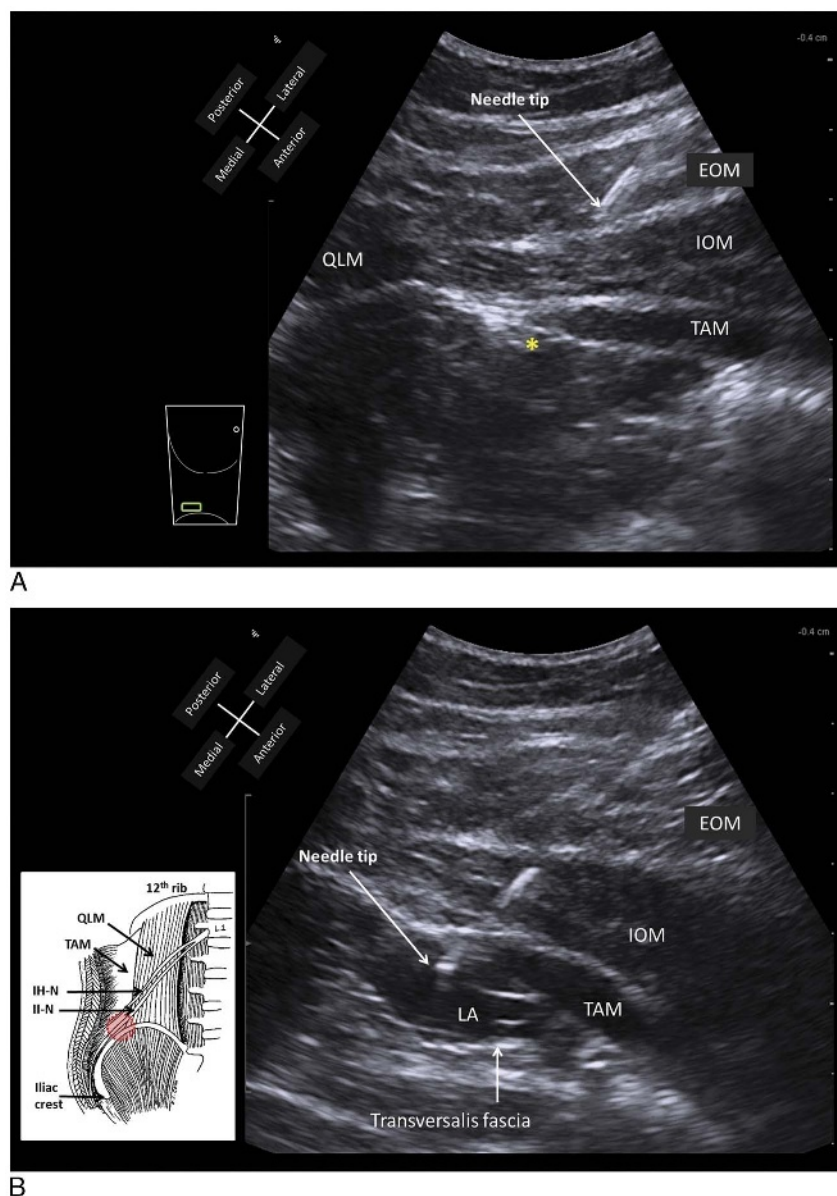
Ultrasound-guided TFP block. A, Preinjection image. The needle is advanced in an anterior-to-posterior direction, aiming to pierce the TAM where it tapers off into its aponeurosis. The target for needle tip position is immediately deep to TAM as indicated by the asterisk. B, Postinjection image. Correct needle tip position is indicated by formation of a visible pocket of local anesthetic (LA) expanding in the plane between TAM and the transversalis fascia, which lines the deep surface of TAM. The II-N and IH-N lie in this location immediately superior to the iliac crest (inset picture). IH-N indicates iliohypogastric nerve; II-N, ilioinguinal nerve; LA, local anesthetic. Reproduced with permission from KJ Chin Medicine Professional Corporation.
